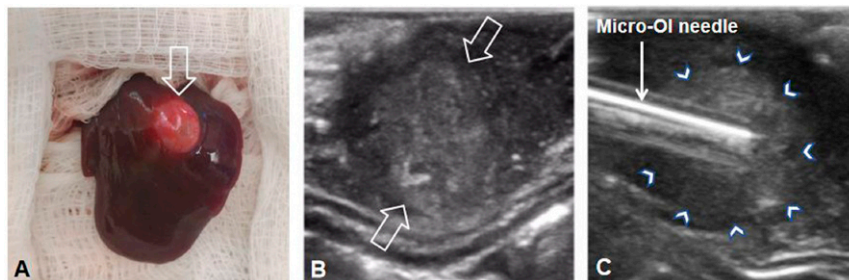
Creation of the rabbit model with VX2 liver tumor. (A) A VX2 liver tumor (open arrow) was successfully created in the left lobe of the rabbit liver, which was detected by ultrasound imaging (between open arrows in B). Under real-time ultrasound imaging guidance, the micro-OI needle could be advanced into the tumor and then precisely positioned at different directions along the tumor margin (arrowheads in C) to detect ICG-outlined residual tumors.
